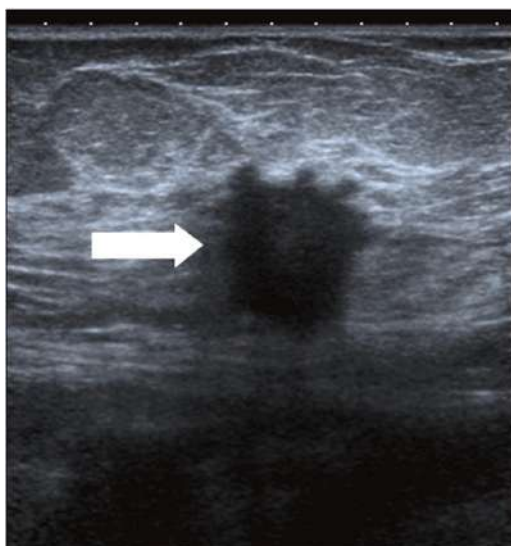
Ultrasound Imaging of a Breast Mass
